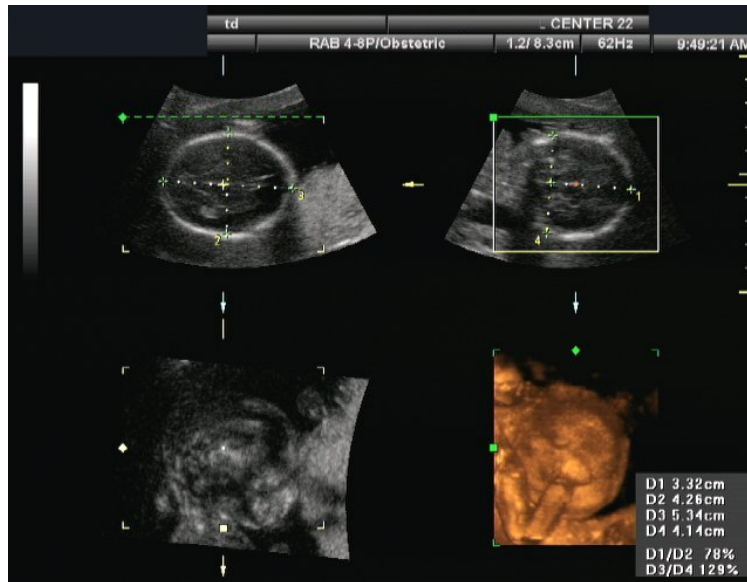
Measurement on 3D Ultrasound Image. A sonographer annotates a 3D ultrasound image of a fetus' head to measure the length and width of the cranium. The 3D volume can be resliced interactively to find the plane of maximum intersection, hence reducing the chances of error with respect to 2D ultrasound, where the operator must find this volume during the acquisition itself. *Image under Creative Commons License (CC-BY-SA 3.0), by Terry J. DuBose over WikiMedia Commons.*
